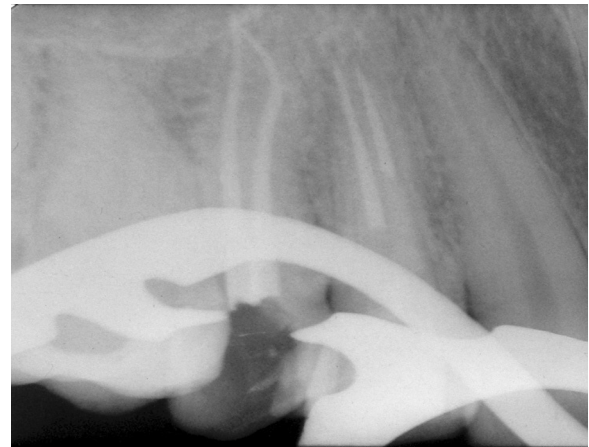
Post-operative radiograph of 1.5. Shaping obtained with ProTaper Next.
